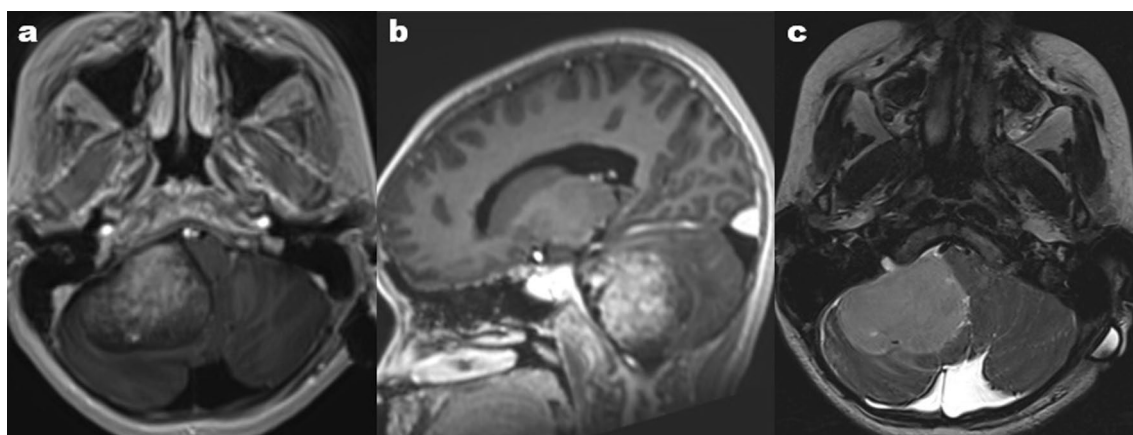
Axial (a) and sagittal (b) views of contrast MRI showing a heterogeneously enhancing mass lesion [size 5.0 (TR) × 4.3 (AP) × 5.0 (CC) cm] in the right cerebellopontine angle. Axial T2 image (c) showing an extraaxial lesion in the right cerebellopontine angle, with focal extension into the internal auditory canal
